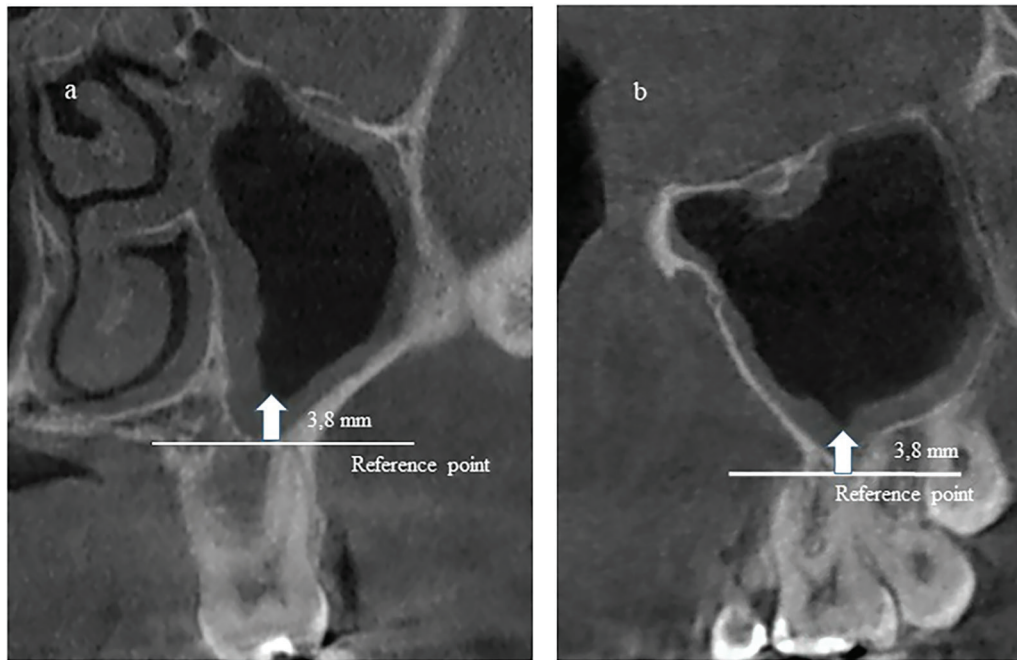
Detailed radiographic demonstration of mucosal thickening measurements. a) Coronal sections b) Sagittal sections.
